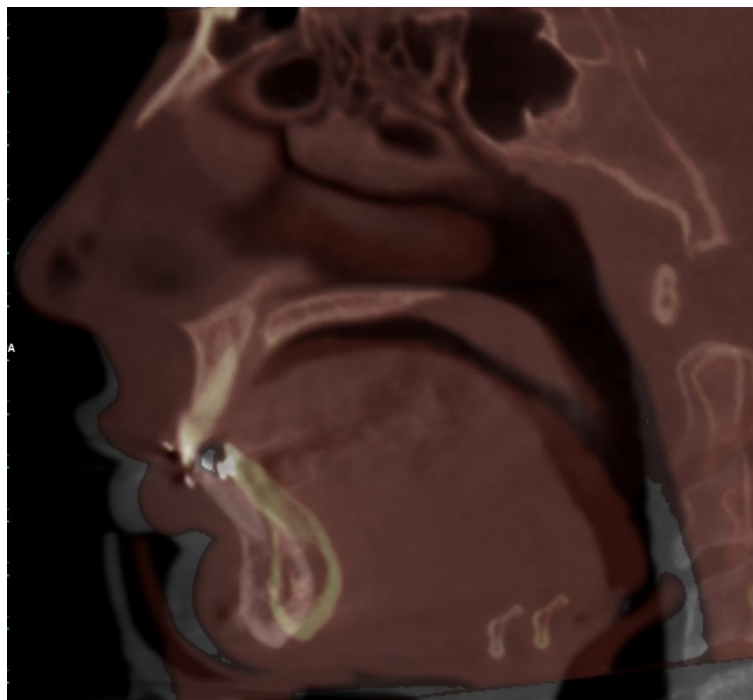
Superimposition of CBCT T0 (green) and T2 (red)
